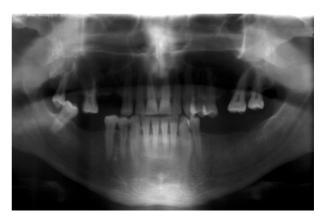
Panoramic radiograph shows NHL lesions arising from maxillary sixth molar extraction sites.
